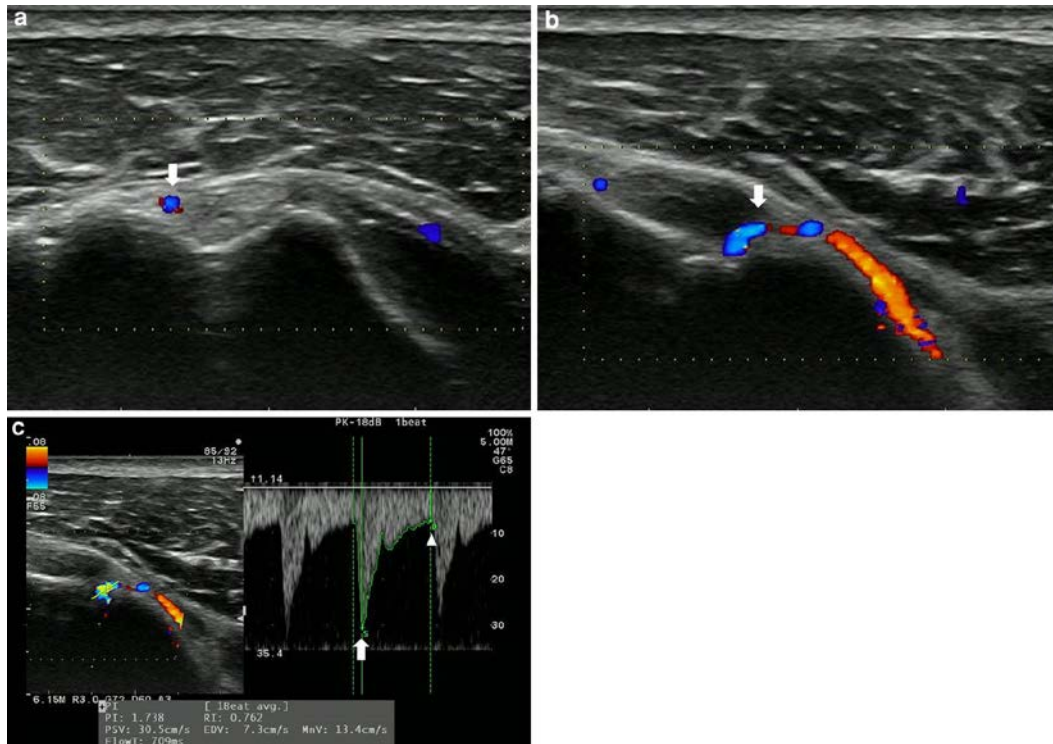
a) Transversal cross section on color Doppler sonography from bicipital groove.
